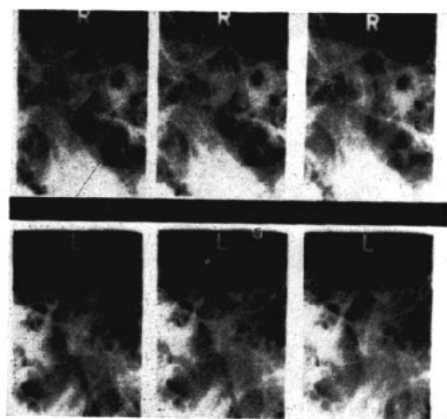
Resultant radiographs using mask shown in Fig. 9.
